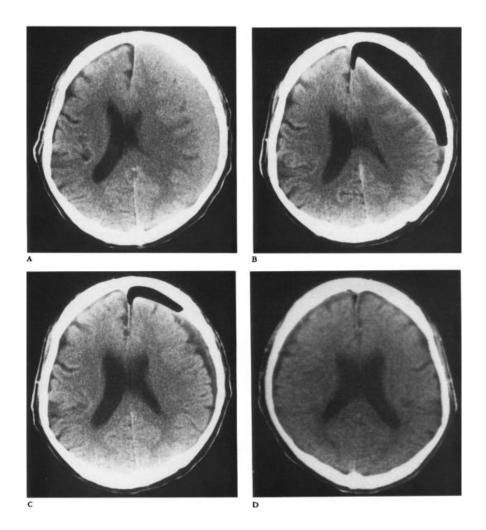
shows a series of CT scans taken before and after replacing the hematoma with oxygen. (A) Before the surgery. (B) Right after the surgery. (C) Two days after the surgery. (D) Eleven days after the surgery.
